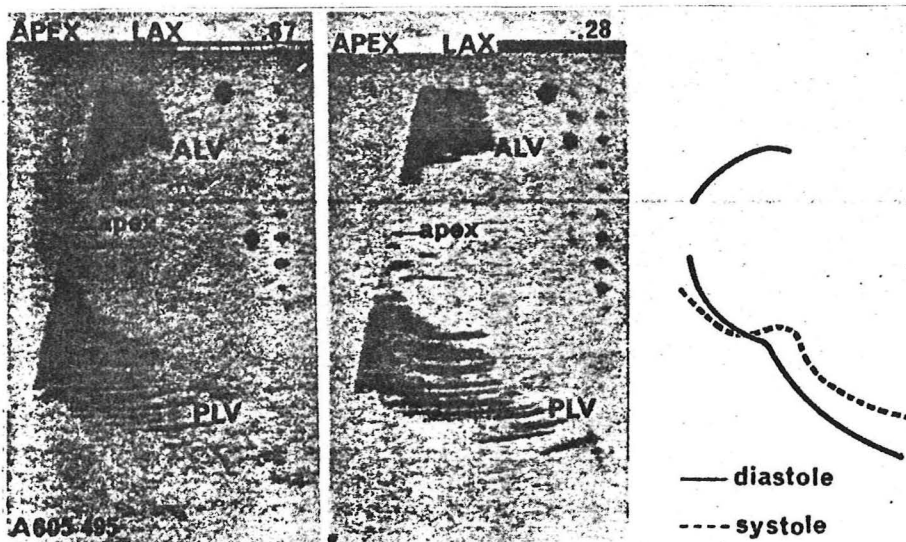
Two-dimensional echocardiogram of the left ventricular apex of a patient with a large apical aneurysm. Abbreviations as in Figure 15 (45).
